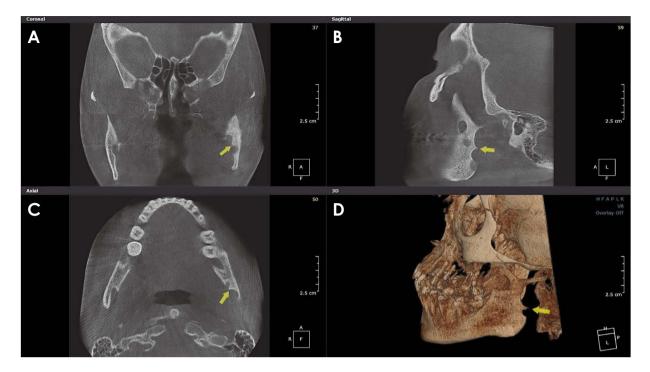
Odontogenic keratocyst on cone-beam computed tomographic images. A. Coronal view shows a scalloped border in the lateral border of the left ramus (arrow). B. Sagittal view shows a scalloped border in the posterior border of the ramus (arrow). C. Axial view shows a scalloped border in the lateral border of the ramus (arrow). D. Three-dimensional surface-rendering image shows a scalloped border in the posterior border of the left ramus (arrow).
